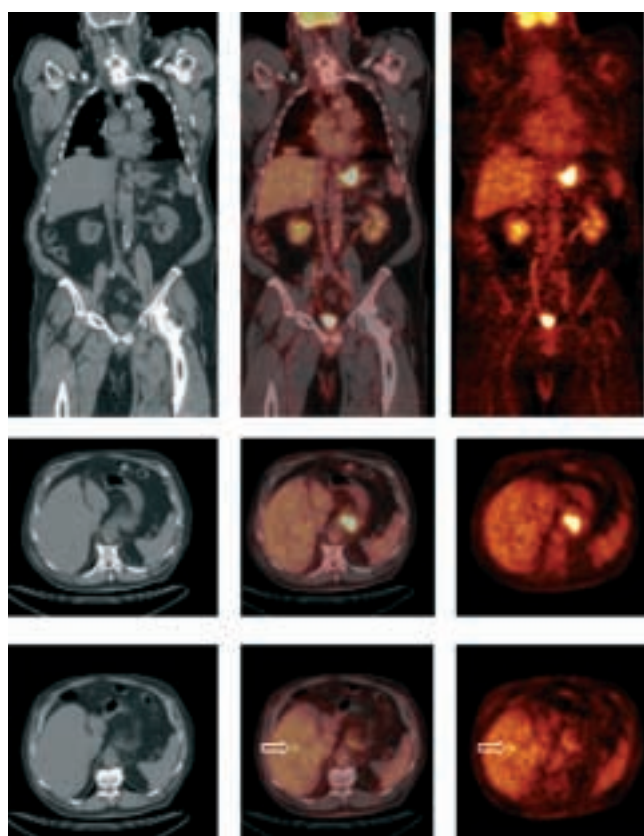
Staging esophageal cancer: 68-year-old man with adenocarcinoma of the gastroesophageal junction. Coronal (*top*) and transaxial (*middle*) CT, PET/CT fusion, and PET images demonstrate intense FDG uptake within the primary tumor mass. Transaxial (*bottom*) CT, PET/CT fusion, and FDG-PET images demonstrate a small focal area of increased FDG accumulation within a 1-cm metastasis in the right lobe of the liver (*open arrows*). The diagnosis of metastatic disease was confirmed by sonographically guided biopsy of the hepatic lesion.
